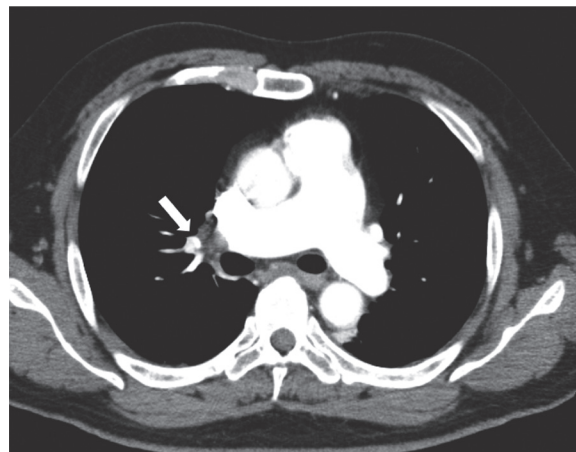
Chest enhanced CT findings on postoperative day 4
